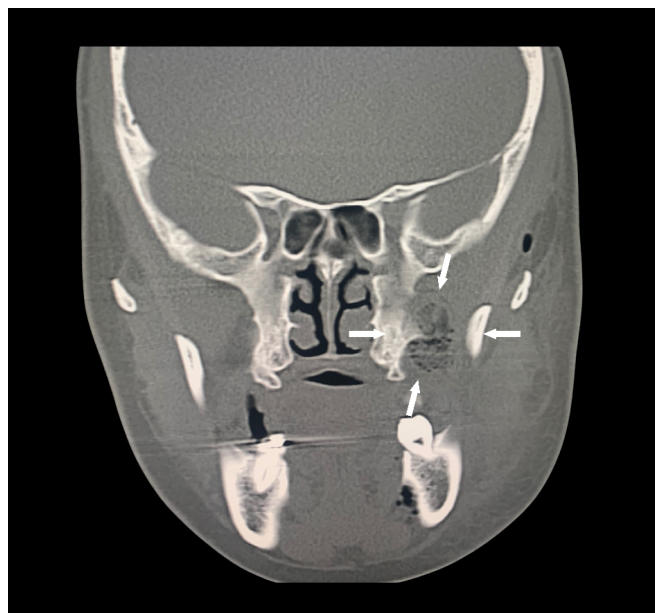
Contrast-enhanced computed tomography scan (CT), coronal section. Spongiform pattern due to presence of gas in the infratemporal area (white arrows).
